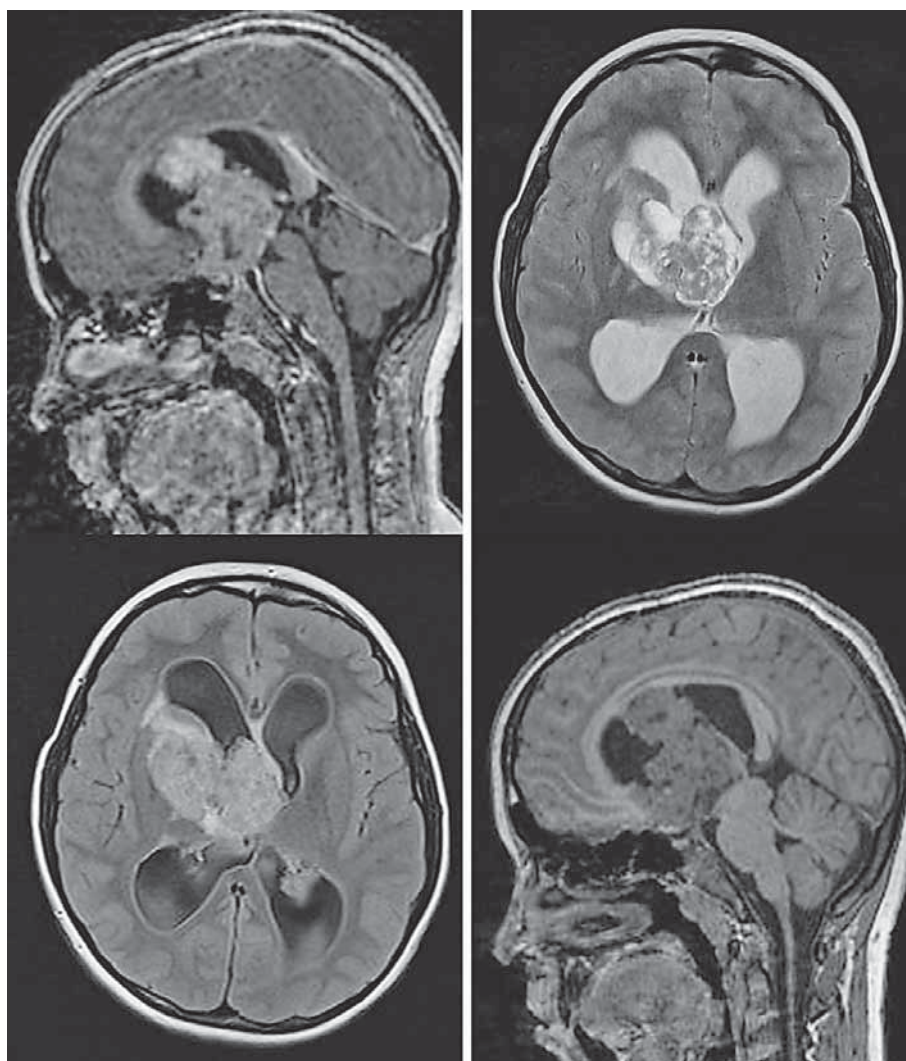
MRI scan showing a large, well-delineated mass measuring 6.3x4.2x5.0 cm, situated suprasellarly, involving the hypothalamic region with cranial extension at the third and right lateral ventricles. T2 sequence showed hypointense areas of calcifications. Post contrast sequence showed focal areas of enhancement. Internal cerebral veins are displaced by the tumor. Basal ganglia at the right side show perifocal edema. Dilated lateral ventricles and morphological loss of gyral and sulcal formations at the cortex are evident.
